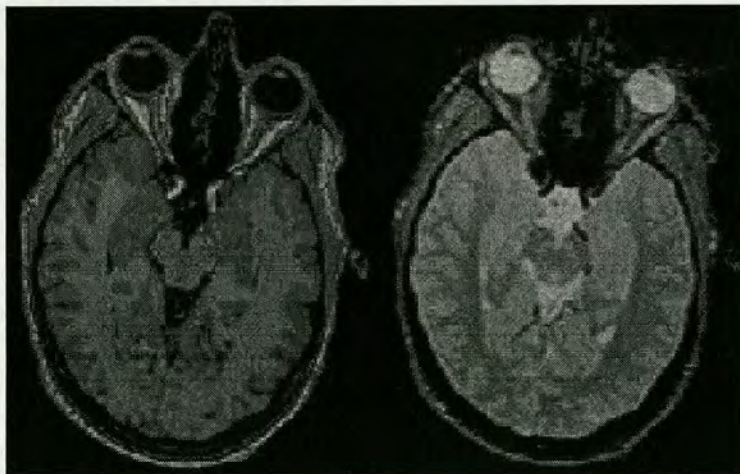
Comparative eye-level axial MRI T_1 (left) and T_2 (right) scans of the Human head demonstrating the different characteristics highlighted by each imaging modality.*
